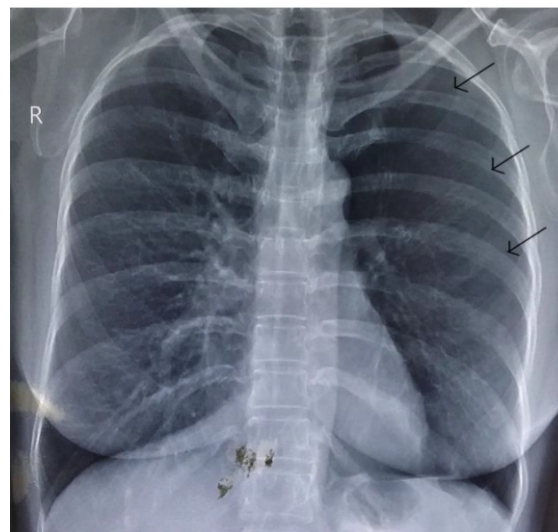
Chest X-ray showing the hyper-lucent left lung due to the reduced ipsilateral vasculature (arrows)
